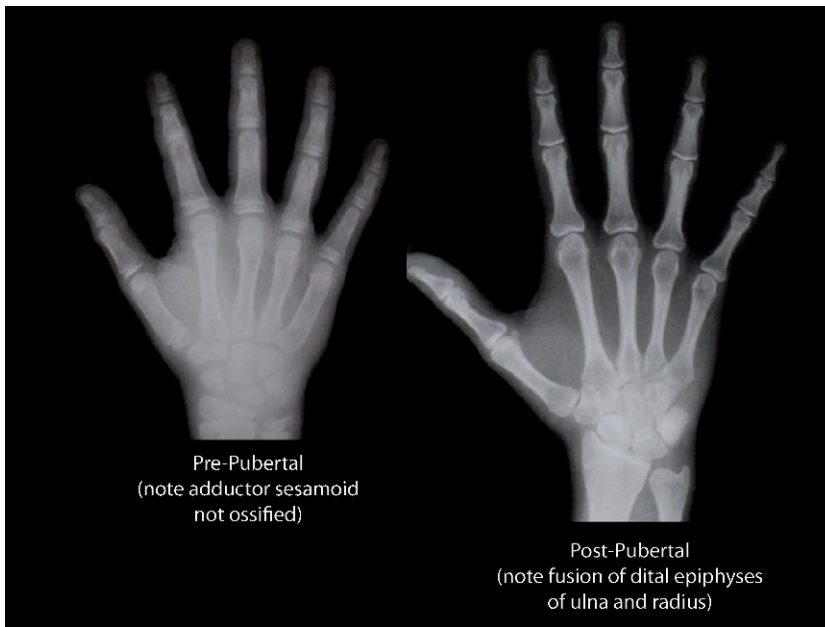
Comparison of hand-wrist radiographs from pre-pubertal patient having significant growth potential (*left*; note adductor sesamoid not ossified), and of post-pubertal individual with little growth potential (*right*; note fusion of distal epiphyses of ulna and radius)
